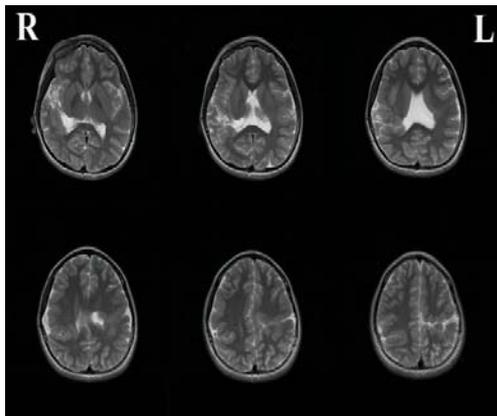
T2-weighted diagnostic brain magnetic resonance imaging.
